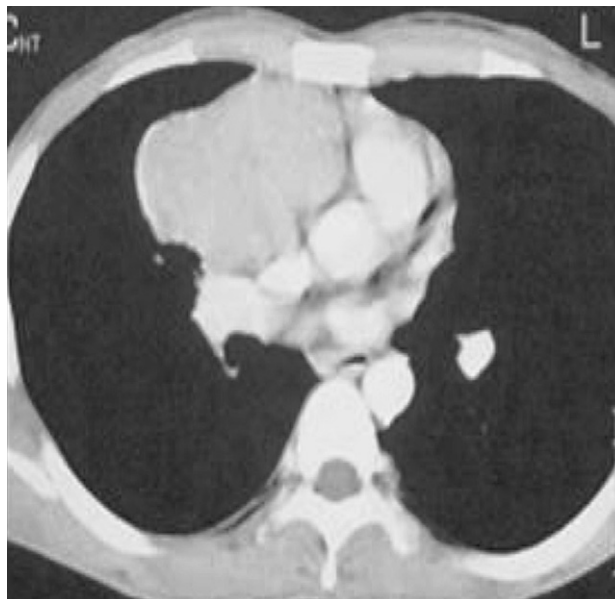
Computed tomographic scanning of the chest: homogeneous tissular mass occupying the anterior mediastinum in its upper and medium stage, extending to the infundibulum without lymph node enlargement.
